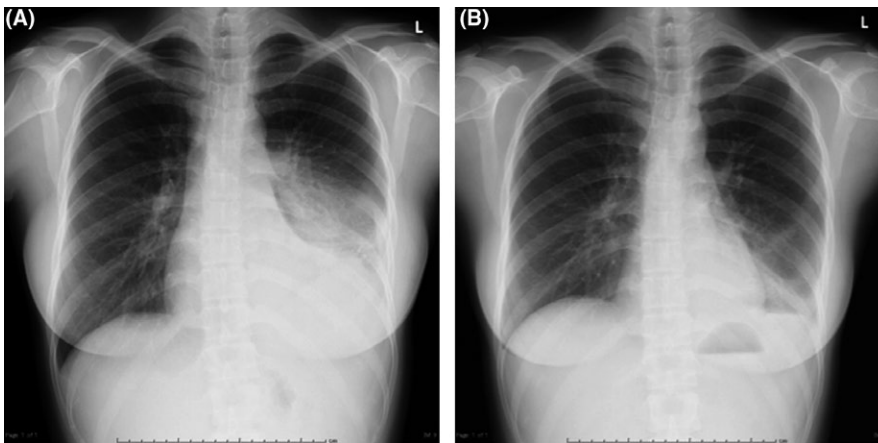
A, Chest radiograph on the 4th day of admission shows left lower lobe consolidation with silhouette sign. B, Chest radiograph on the day of discharge shows improvement of left lower lobe consolidation
